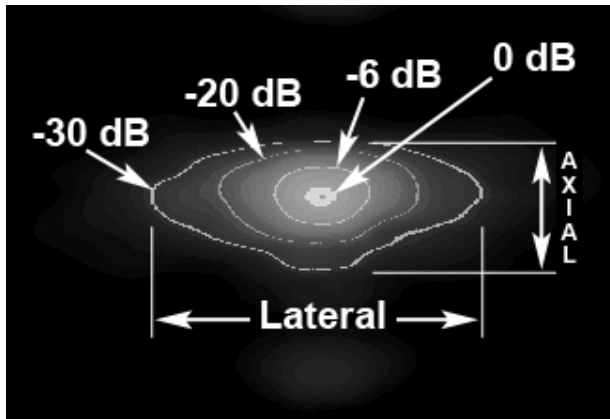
Ultrasound system point spread function. The dimensions labeled “Lateral” and “Axial” represent the -30 dB lateral and axial resolution.
